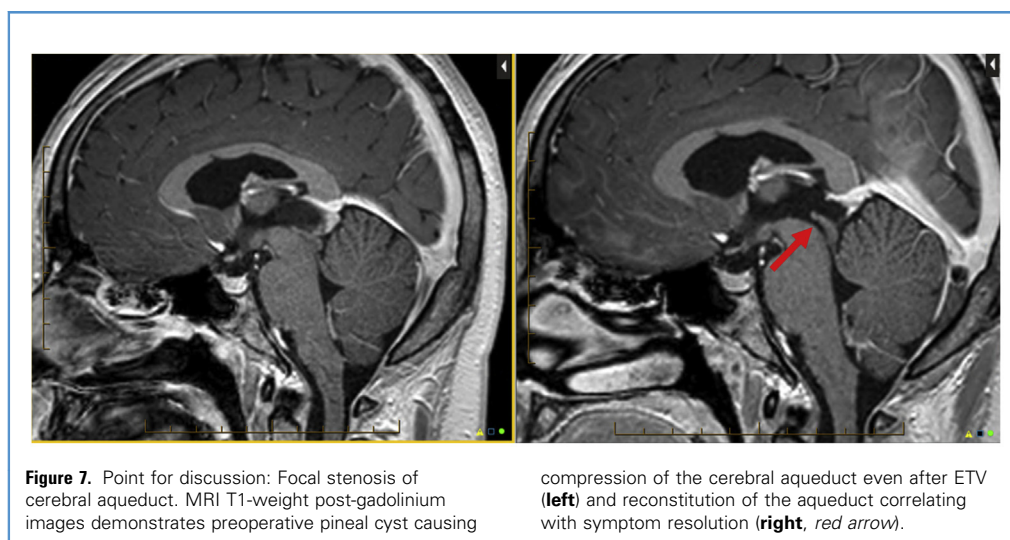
Point for discussion: Focal stenosis of cerebral aqueduct. MRI T1-weight post-gadolinium images demonstrates preoperative pineal cyst causing
